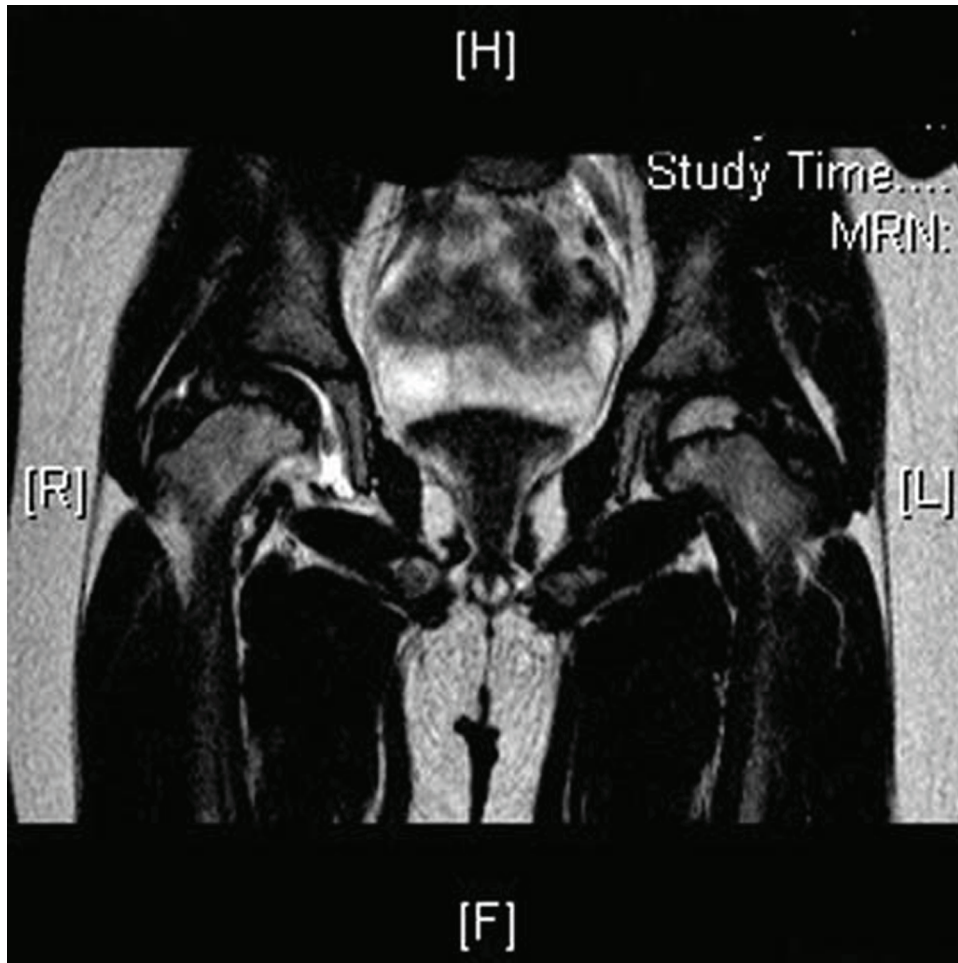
MRI demonstrating avascularity of the right femoral epiphysis.
